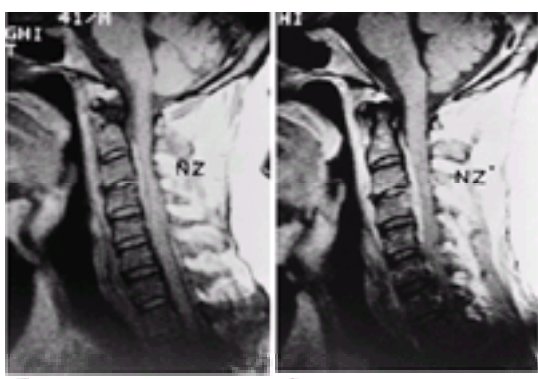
Ventral cervical epidural abscess associated with hematogenous intervertebral discitis. Sagittal MR images (a) before and (b) after the administration of gadolinium. Note the significant enhancement of the abscess with use of paramagnetic contrast.
